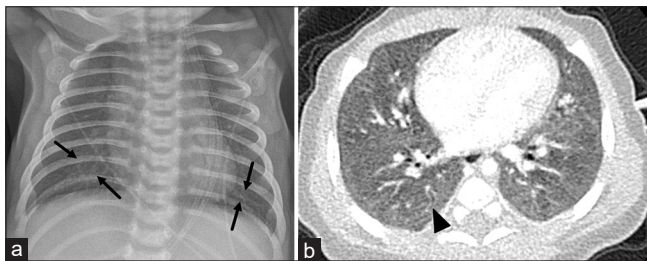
A 15-day-old term infant with respiratory distress, pathologically proven to have alveolar capillary dysplasia by bronchoscopy and tissue sample. (a) Chest radiograph shows a background of diffuse granular opacifications with peribronchial wall thickening (black arrows). (b) Axial chest computed tomography image better demonstrates diffuse ground-glass opacifications with peribronchial wall thickening (arrowhead)
